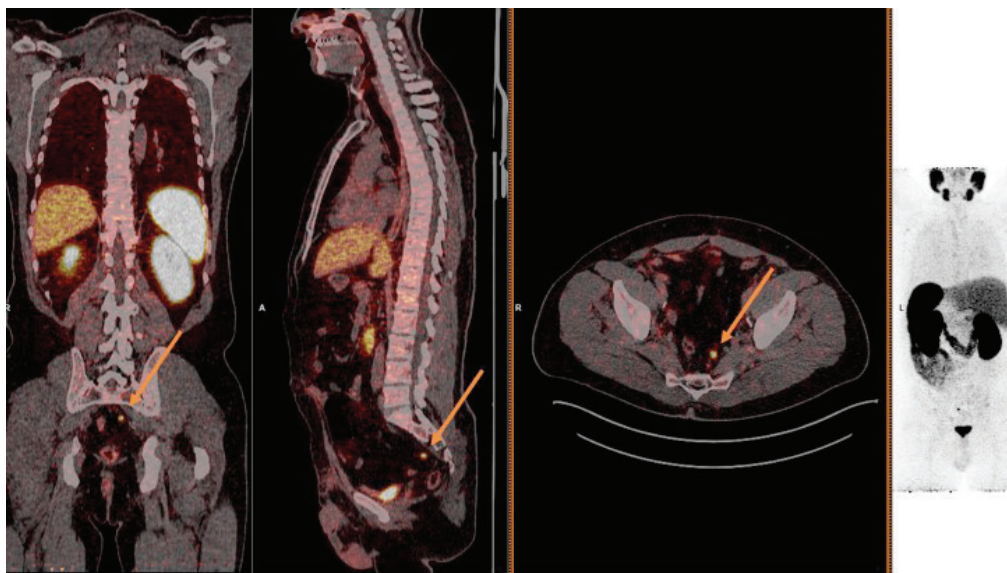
Presacral lymph node metastasis in a patient with PSA 0.22 ng/mL. The patient had radical prostatectomy 9 years before BCR and PSAdt of only 4 months. SUVmax 35.
